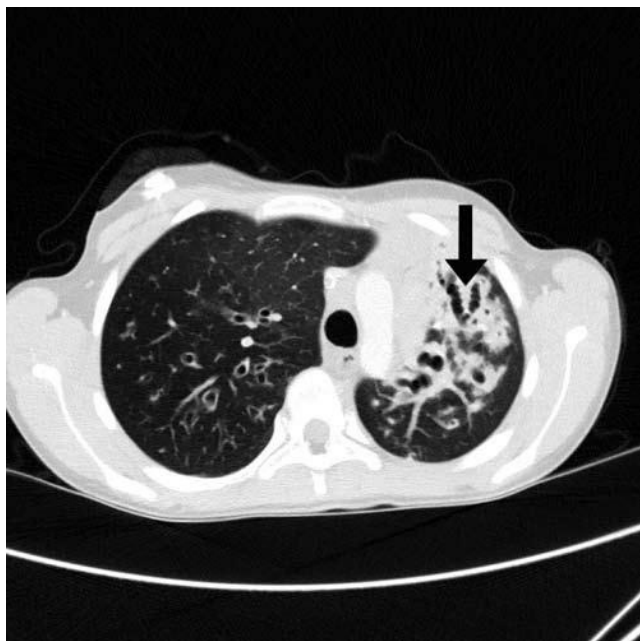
Chest CT scan of a 13.5-year old girl with AI and CF shows significant retraction of the left lung, severe cirrhotic changes and bronchiectasis in the upper lobe. Saccular bronchiectasis seen in the left upper lobe – denoted by arrow. The displacement of the mediastinum to the left, with herniation of the right lung to the left. Patient after an ineffective antifungal treatment underwent a left pneumonectomy. (CT was performed in the Department of Diagnostic Imaging of the Institute of Mother and Child in Warsaw).
